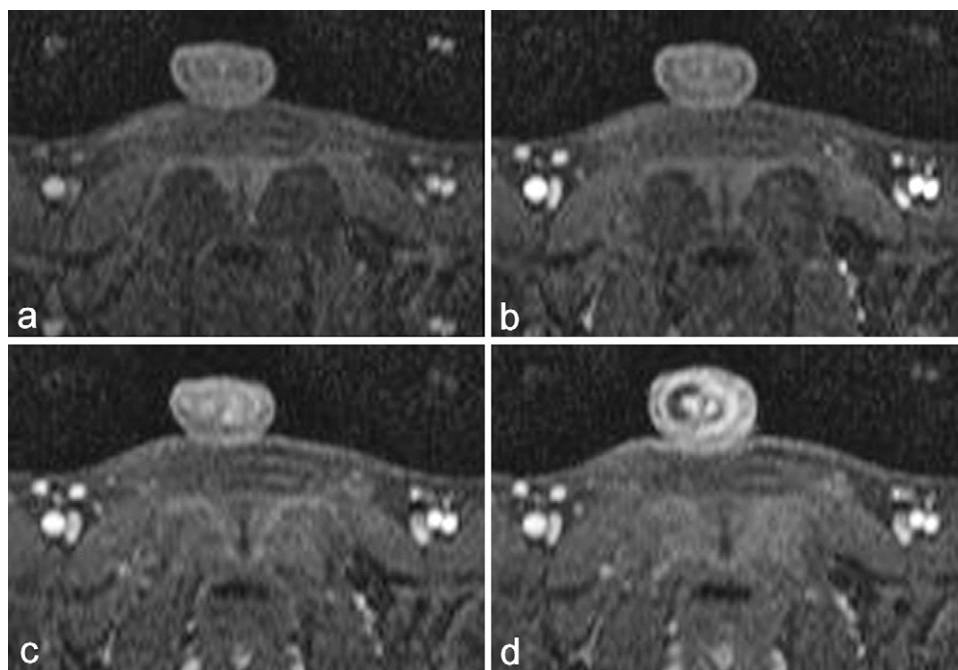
Transverse fat-suppressed gradient-echo T1-weighted images before (a) and 30 s (b), 90 s (c), and 150 s (d) after intravenous injection of contrast material, showing peripheral enhancement of the tumour and delayed central enhancement via the central penile arteries.
